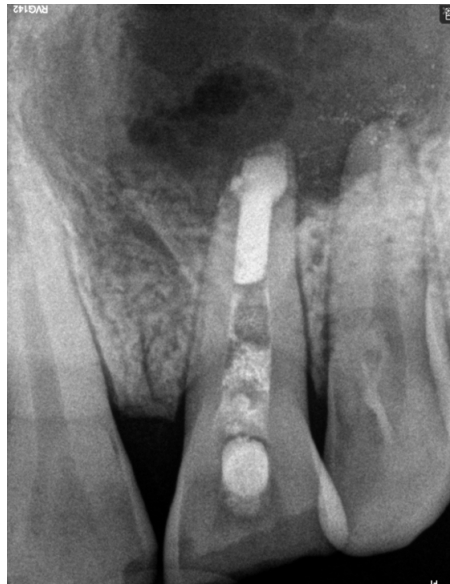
Preoperative IOPA radiograph
